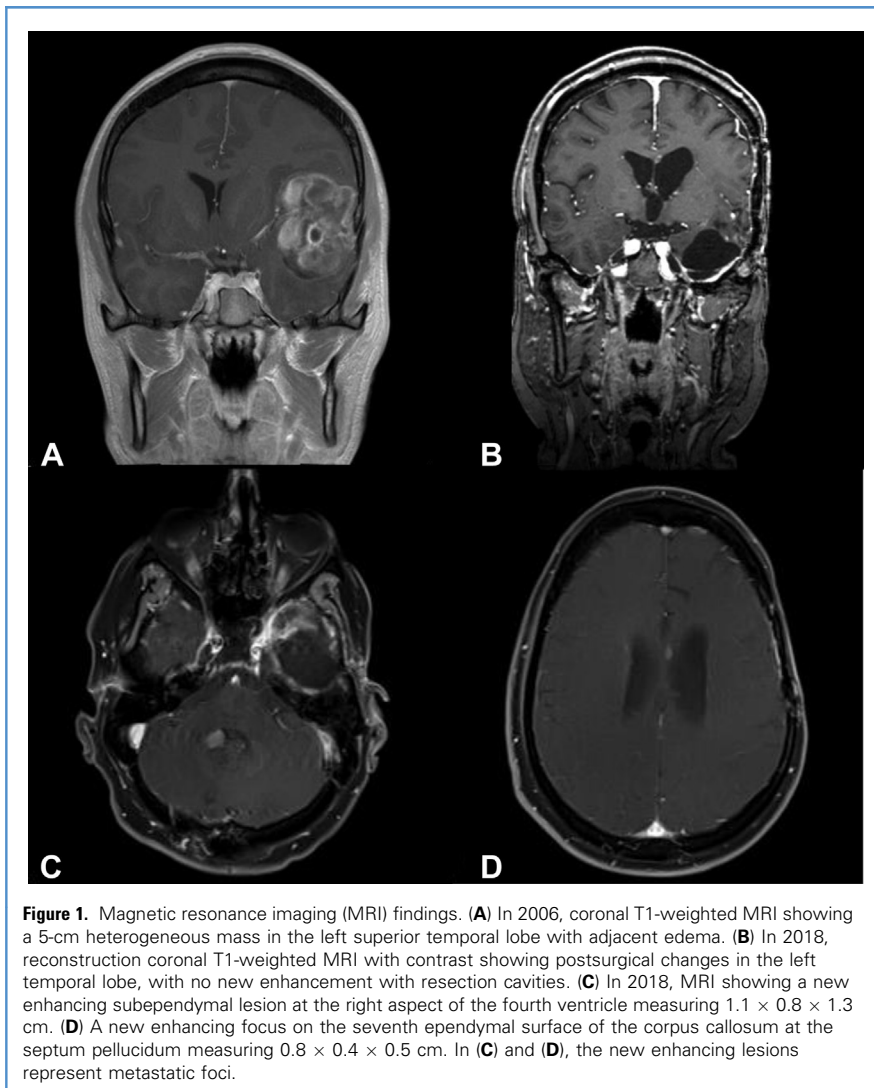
Magnetic resonance imaging (MRI) findings. (A) In 2006, coronal T1-weighted MRI showing a 5-cm heterogeneous mass in the left superior temporal lobe with adjacent edema. (B) In 2018, reconstruction coronal T1-weighted MRI with contrast showing postsurgical changes in the left temporal lobe, with no new enhancement with resection cavities. (C) In 2018, MRI showing a new enhancing subependymal lesion at the right aspect of the fourth ventricle measuring $1.1 \times 0.8 \times 1.3$ cm. (D) A new enhancing focus on the seventh ependymal surface of the corpus callosum at the septum pellucidum measuring $0.8 \times 0.4 \times 0.5$ cm. In (C) and (D), the new enhancing lesions represent metastatic foci.
